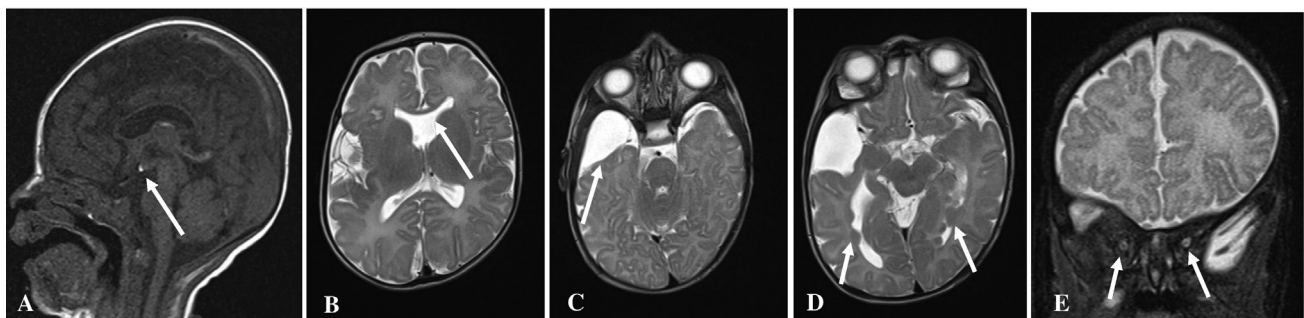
A 3-year-old male child patient presented with multiple episodes of seizures and developmental delay. Sagittal T1-weighted (T1W) and axial T2W magnetic resonance imaging (MRI) images demonstrating ectopic T1W bright spot, located at the median eminence with associated absent septum pellucidum, right anterior temporal arachnoid cyst, periventricular heterotopia, and bilateral hypoplastic optic nerves. Isolated growth hormone deficiency was elicited on hormone analysis.
